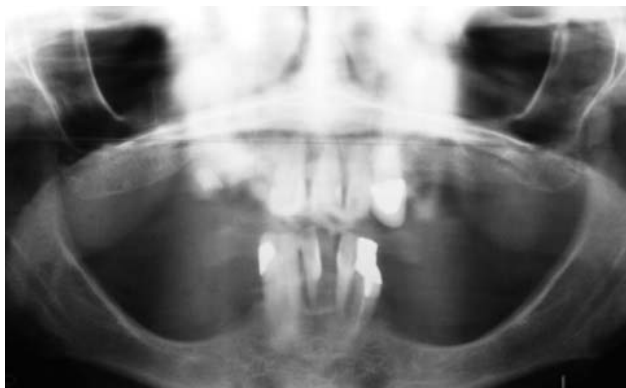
Preoperative panoramic radiograph from a 57-year-old female who received the treatment in both jaws on the same day. The patient had periodontally compromised teeth in both the maxilla and the mandible. After extraction of all teeth, curettage, and bone ridge adjustments, implants were placed according to the protocol. The case demonstrates a commonly encountered clinical situation, and the level of experience with the procedure for its execution was medium.
